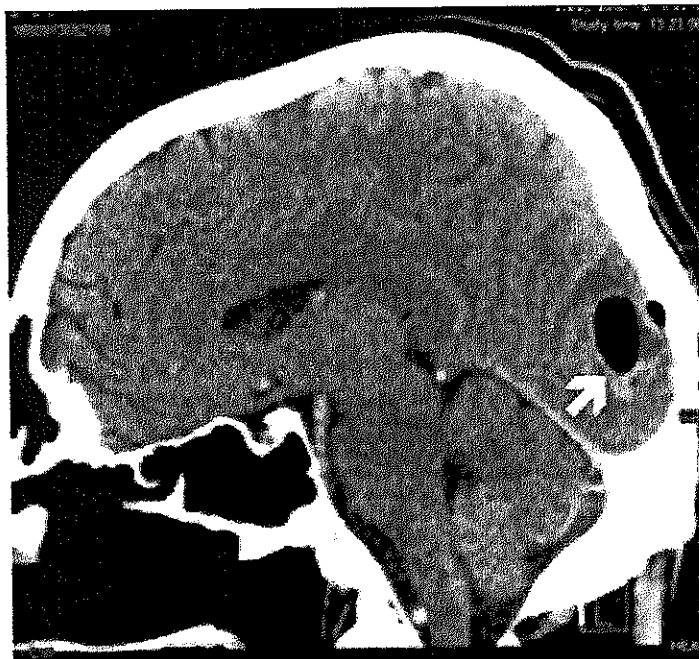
Multiplanar sagittal reconstruction after cerebral computed tomography: air-filled cavity, secondary to abscess evacuation (arrow).
